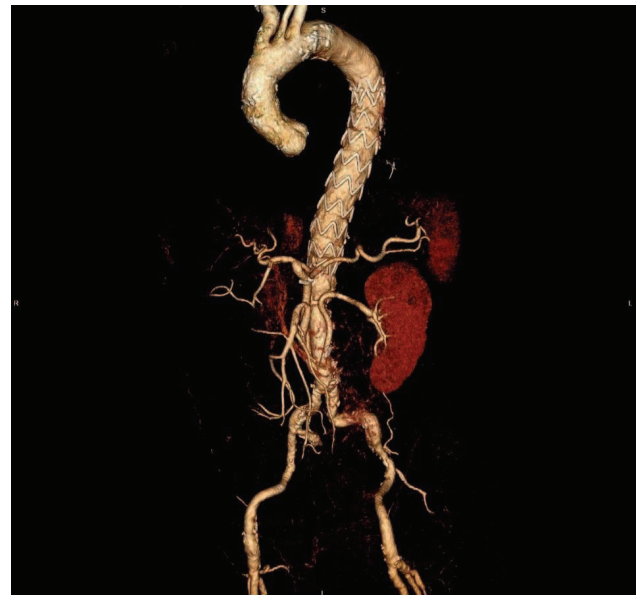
Postoperative computed tomography (CT) of the same patient with type III thoracoabdominal aortic aneurysm (ThAAA).
